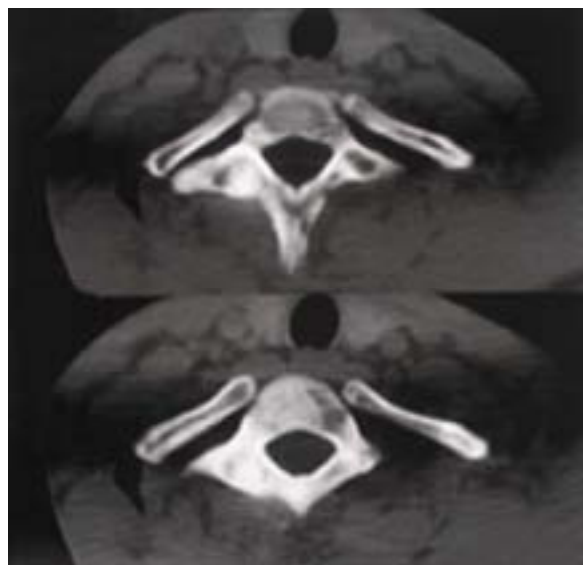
Axial CT scan of lamina
